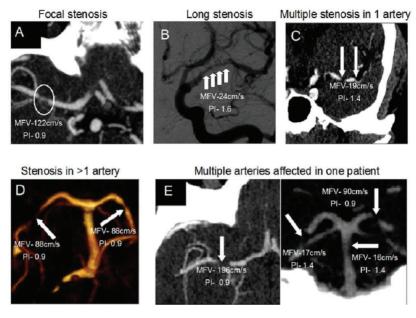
Patterns of stenosis noted on CT angiography.
